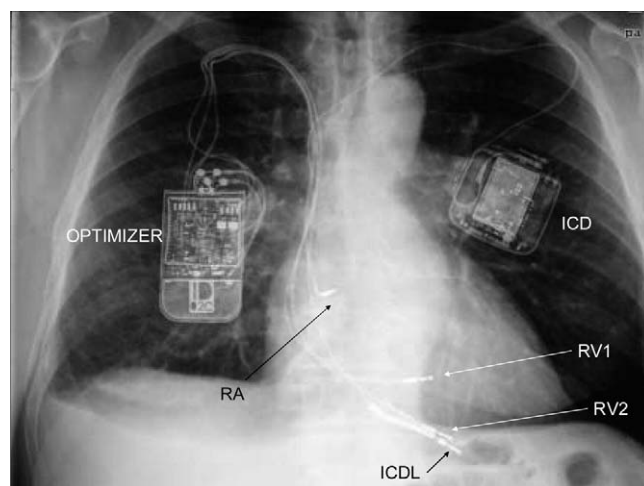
Chest x-ray film of a patient implanted with an OPTIMIZER system in the right subclavian region and an implantable cardioverter-defibrillator (ICD) in the left subclavian region. The associated two right ventricular leads (RV1 and RV2), right atrial lead (RA), and ICD lead (ICDL) are also seen.
